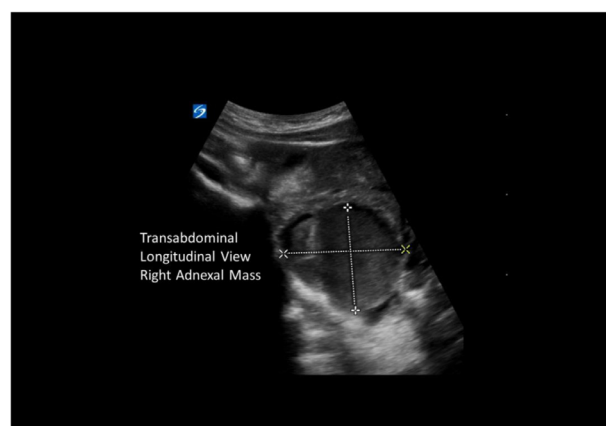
This image is the right adnexa in the transabdominal longitudinal view on ultrasound. It depicts a large heterogeneous mass in the right adnexa. Concern for ruptured ectopic pregnancy.
